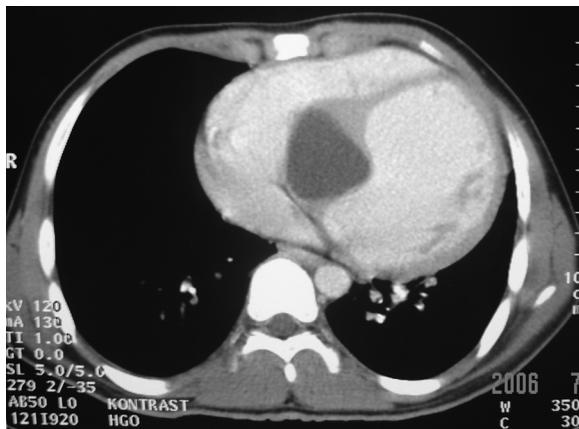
Appearance of the hydatid cyst on a computed tomography scan.
